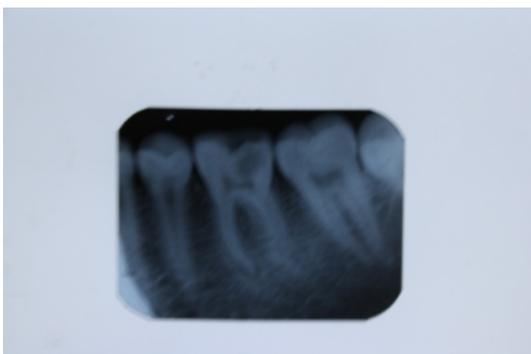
Pre operative intra oral radiograph of left mandibular molar with deep occlusal caries
